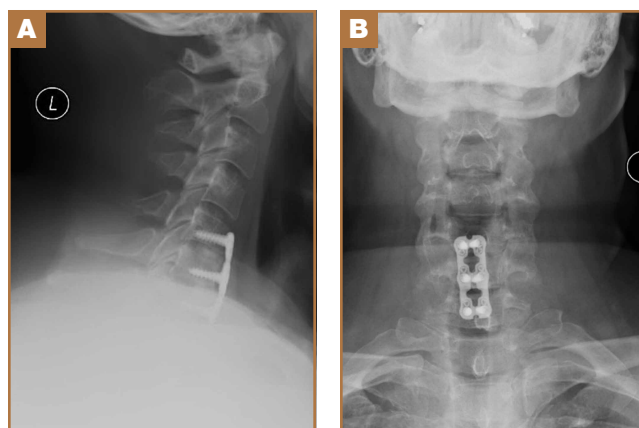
Postoperative (A) lateral and (B) anteroposterior radiographs, showing adequate hardware placement.
